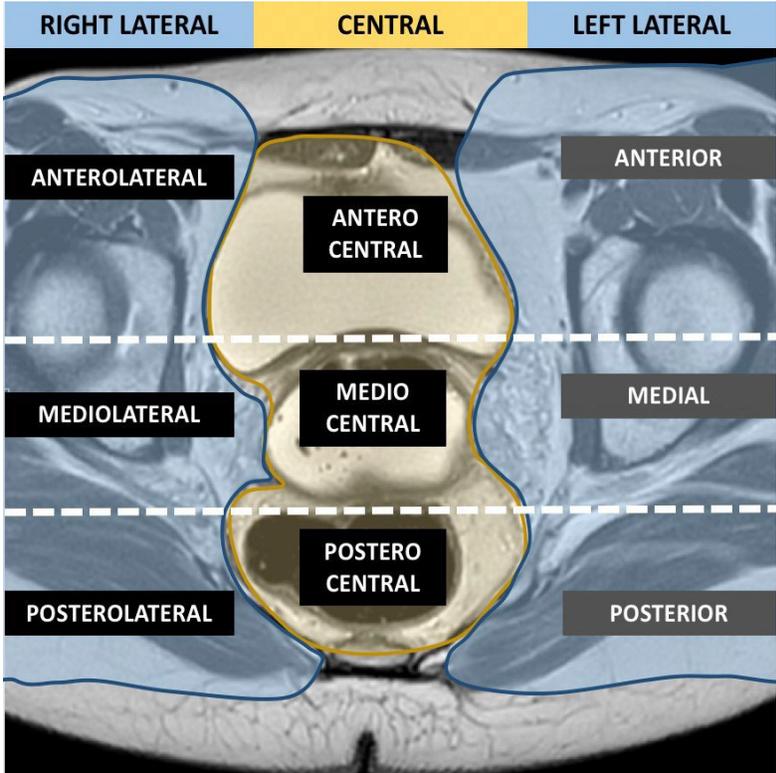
MRI lexicon and deep pelvic endometriosis index (dPEI) classification. Low extension (score 1 or 2), Moderate extension (score 3 or 4) and severe extension (score 5 or more) [74].
